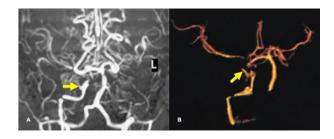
Brain MRA (A) and CTA (B) showing asymmetric stenosis of the anterior circulation with an extensive vascular network at the basal ganglia. The right ICA shows stenosis with near-occlusive narrowing of its supraclinoid segment extending to a few millimeters of the right ACA & MCA.
